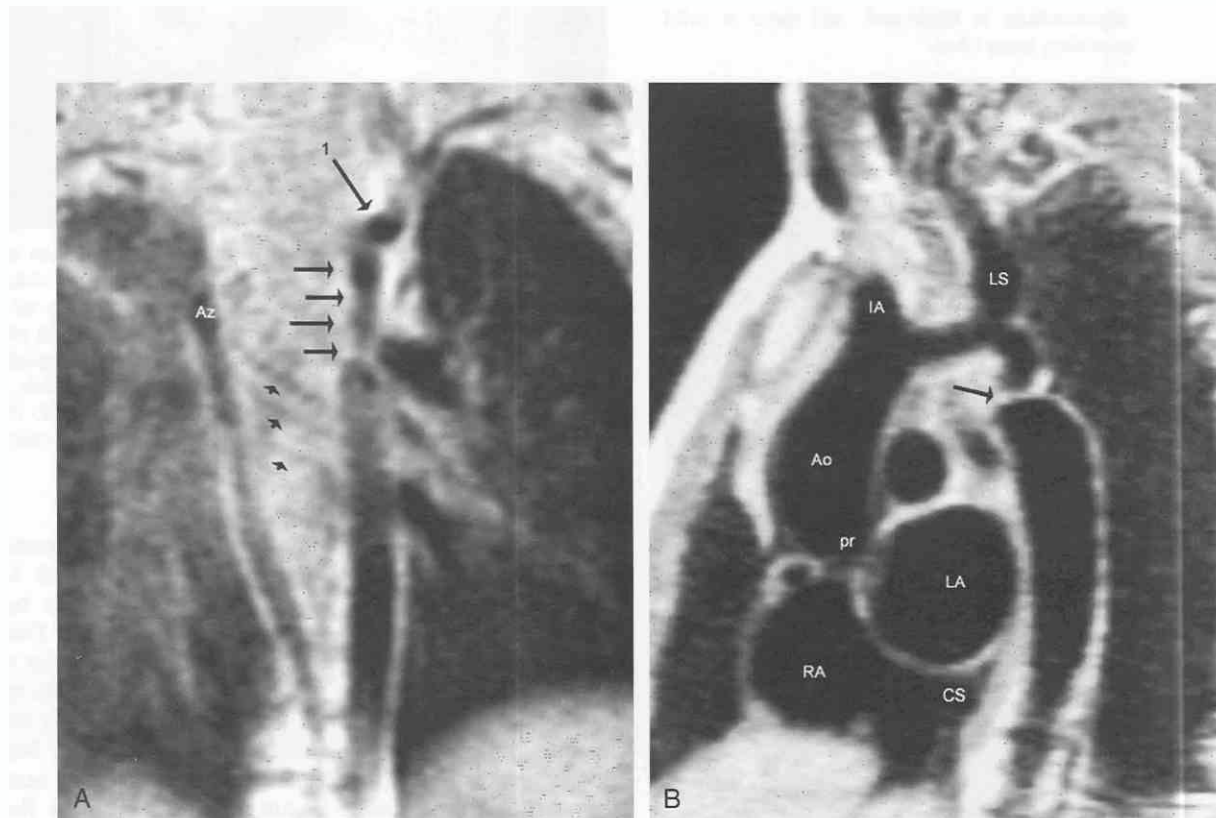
MR image obtained from two children with coarctation of the aorta. *A*, Coronal spin-echo acquisition from a 6-month-old girl with a 50-mm aortic gradient. The proximal descending aorta (parallel long arrows) distal to the origin of the dilated left subclavian artery (arrow 1) tapers to the point of maximal stenosis. Aortic collateral vessels (arrowheads) are seen entering the aorta distal to the coarctation. The azygos vein (Az) is labeled. *B*, The patient is a 4-year-old boy with a 60-mm gradient. Left anterior oblique sagittal spin-echo acquisition through the posterior right (pr) aortic sinus of Valsalva. The left (LA) and right (RA) atria are marked. The ascending aorta (Ao) is mildly dilated, and there is hypoplasia of the arch extending from the origin of the innominate artery (IA), beyond the origin of the left subclavian artery (LS) to the actual coarctation itself (arrow). Beyond the coarctation, there is mild poststenotic dilatation. CS, coronary sinus.
